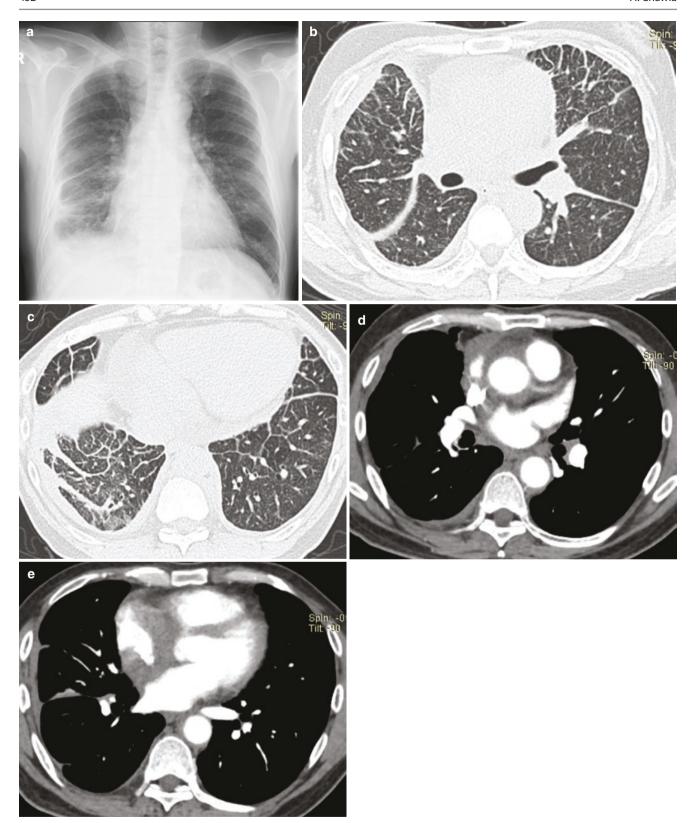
A 58-year-old man with Erdheim-Chester disease. (a) Frontal chest radiograph shows cardiomegaly with right pleural effusion, round atelectasis, and septal thickening in lower lungs. (b, c) Axial CT images show septal thickening, pleural effusion, and an area of round atelectasis
